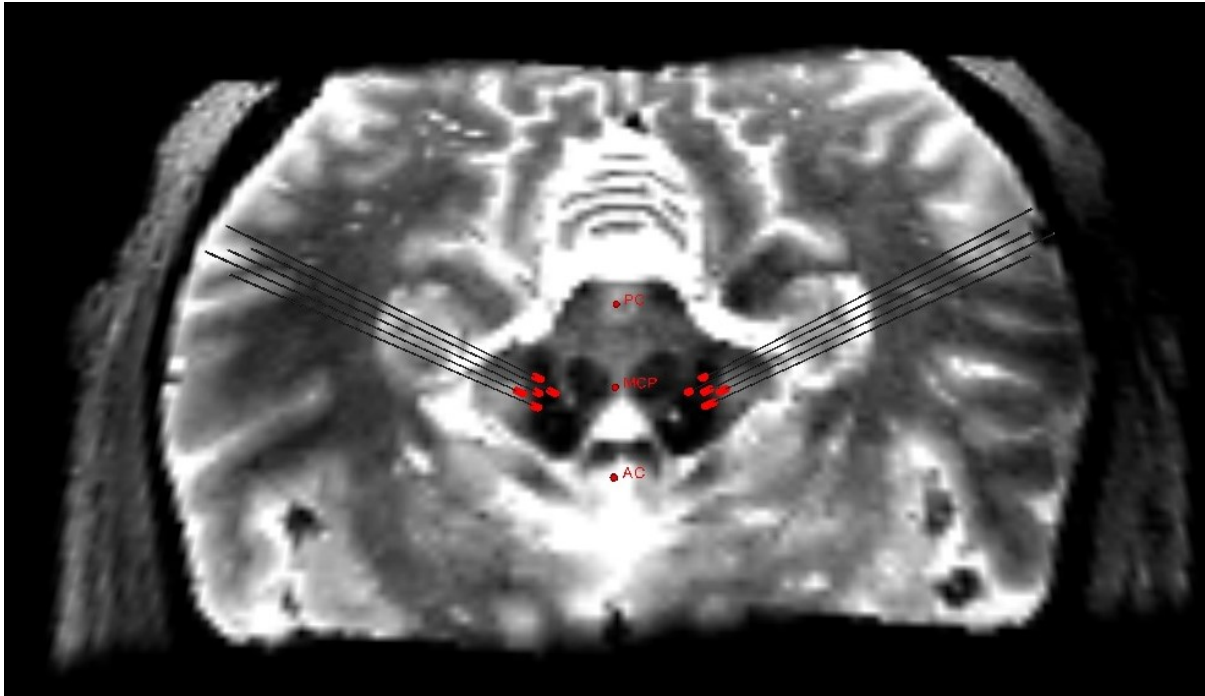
Microelectrode trajectory reconstruction. The red lines indicate the depths that the neurosurgeon decided the microelectrodes are inside the STN. The reconstructions and visualizations were performed using custom Python codes, the Visualization Toolkit, and 3D Slicer v4.8 (<https://www.slicer.org>). T2-weighted 7T images were co-registered to the pre-operative CT image containing the Leksell frame. Images were converted to the NIFTI file format using `dcm2niix` [13]. Co-registration was performed using rigid registration tools in `Niftyreg` [14]. The coordinates of the microelectrode trajectories were extracted from `Stealthstation` (Medtronic Corp, MN).
